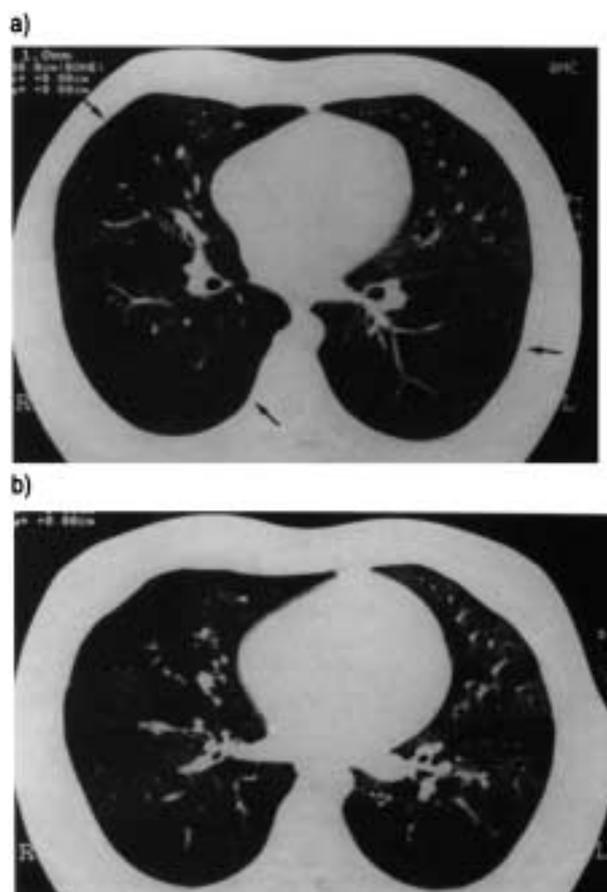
Patient No. 1. a) High-resolution computed tomography (HR-CT) scan during inspiration, showing bilateral diminished parenchymal attenuation (arrows) without normal anteroposterior gradient lung attenuation. Vessels in the hyperlucent regions are sparse and attenuated. b) HR-CT on expiration, showing marked air-trapping.
